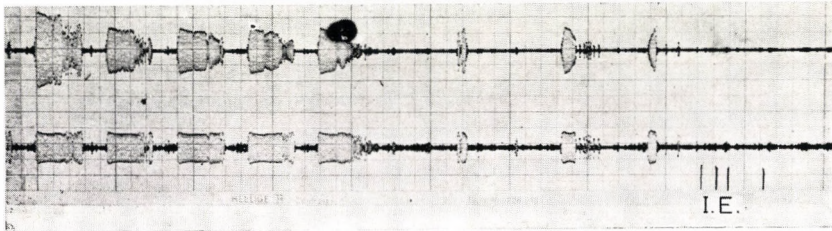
Phonorespirogram, chest X-ray and picture of the vocal chords, during grunting. The chest X-ray reveals good aeration during the inspiratory phase. At the beginning of expiration, the larynx is closed and there is hardly any change in aeration. During the period of grunting, there is a rapid decrease in aeration, the vocal chords are open
